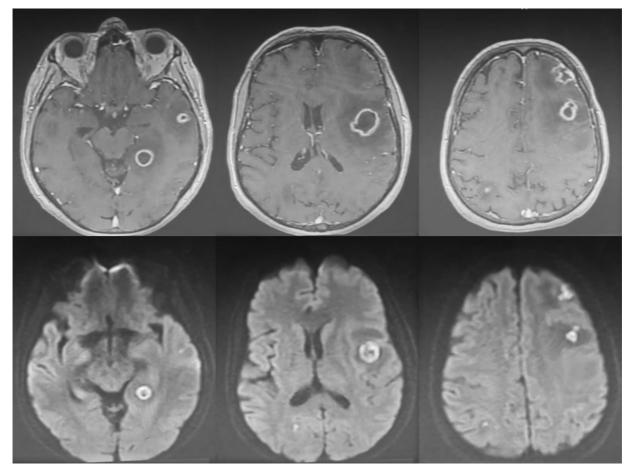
Brain magnetic resonance imaging (MRI) scan showing\ multiple hypointense brain lesions with a halo of enhancement and surrounding edema on a T1-weighted image (above). Diffusion-weighted imaging (DWI) (below) showing hyperintense lesions.
